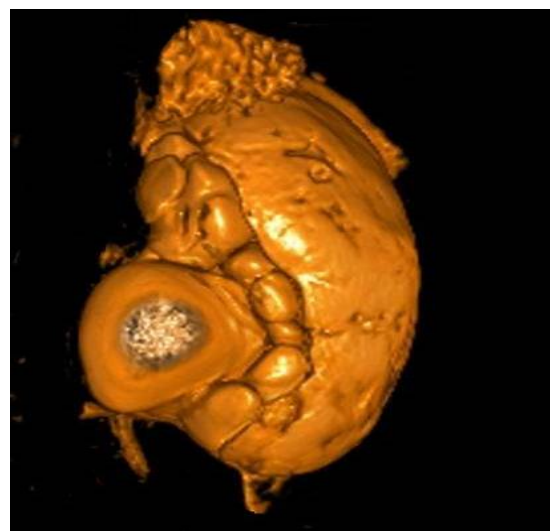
Abdominal MRI (reconstruction).
